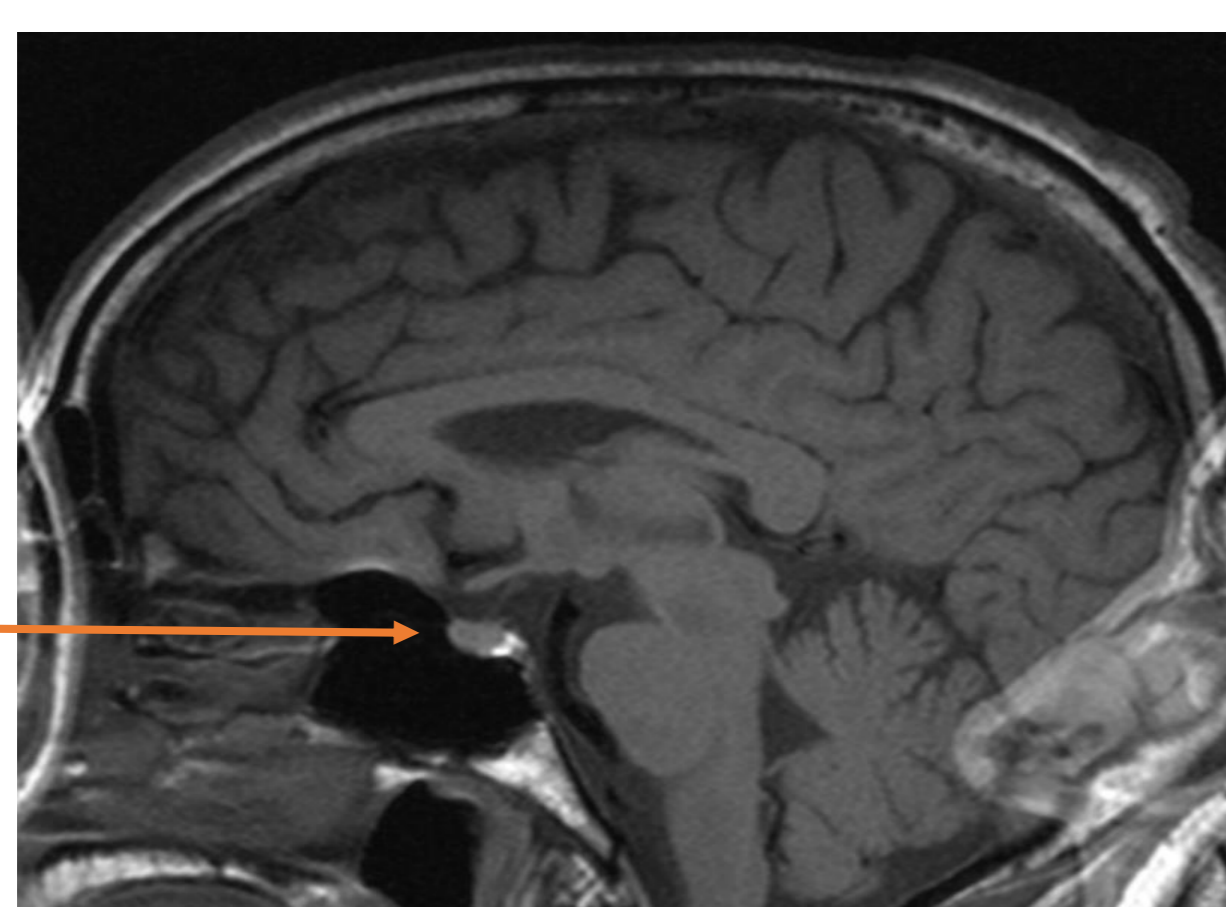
Sagittal MRI scan showing a normal pituitary
